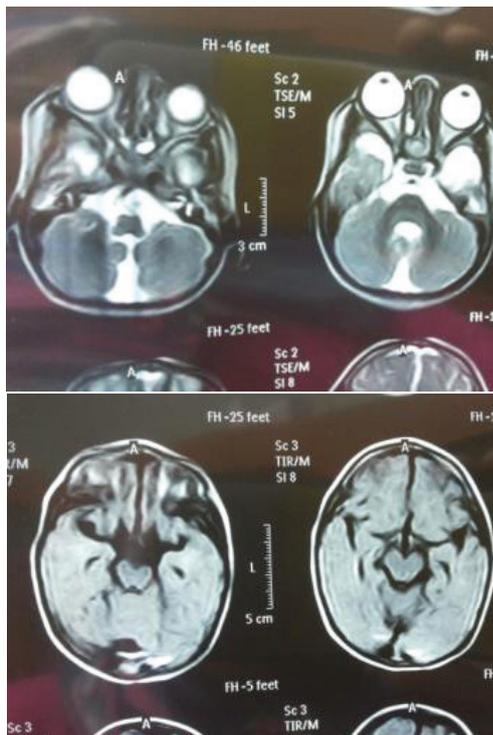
Brain MRI scan of younger sibling revealed reduced volume of white matter and retro-cerebellar cyst.
